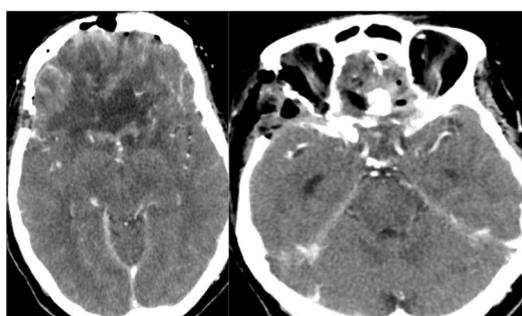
postop. contrast CT scan -ethmoidal sinus remaining tumor
